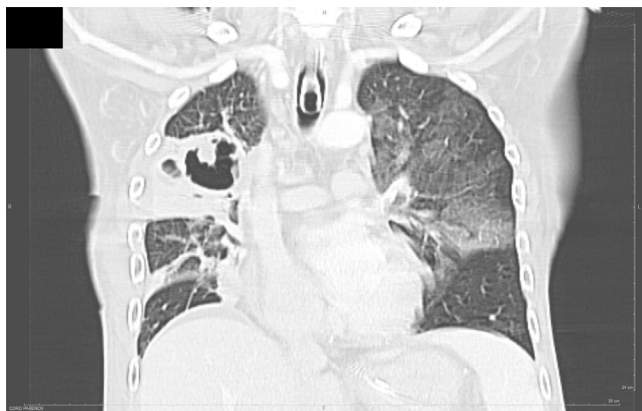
Thoracic CT-scan showing a necrotizing pneumonia with abscess of the upper right lobe.
